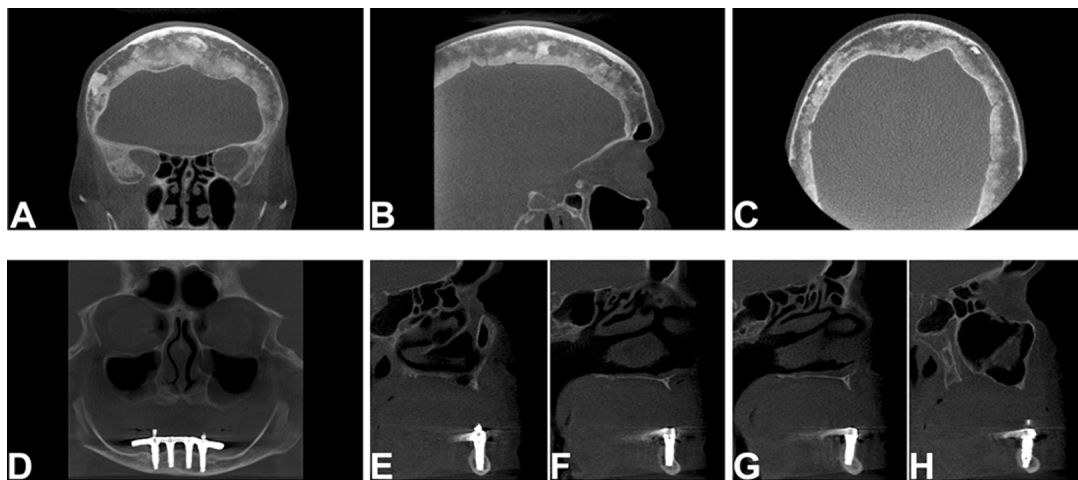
Cone beam tomography showing hyperdense images in the frontal and parietal bones, featuring a predominance of sclerotic areas (A, B and C). The panoramic image (D) and para-axial slices (E, F, G and H) show hyperdense areas related to the implants. Radiographic controls after four years.
